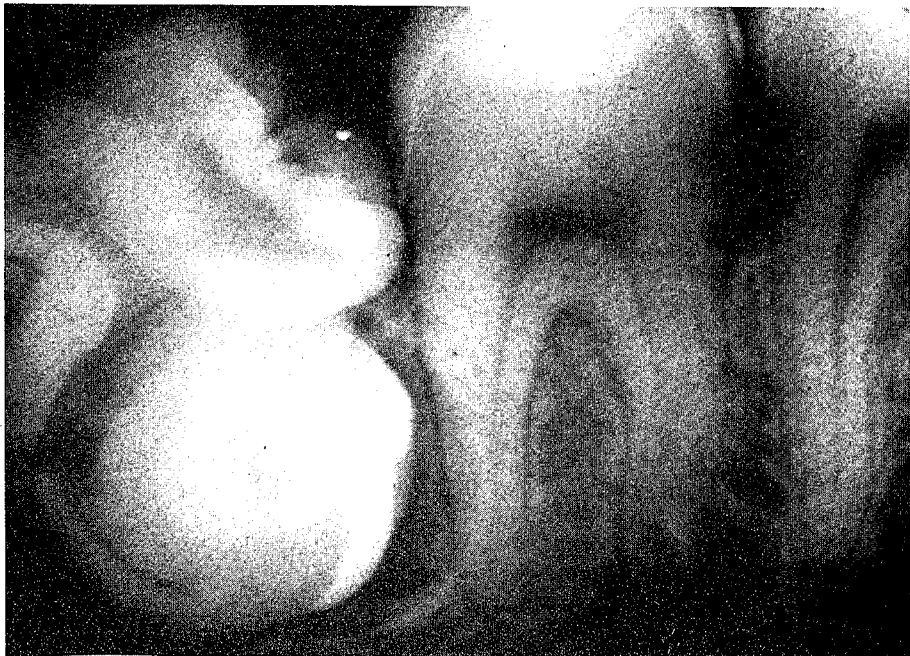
Periapical radiograph of the affected tooth disclosed fusion of the mandibular right third molar with a supernumerary interradicular molar. A balloon shaped invagination arose from the crown of the supernumerary molar.
